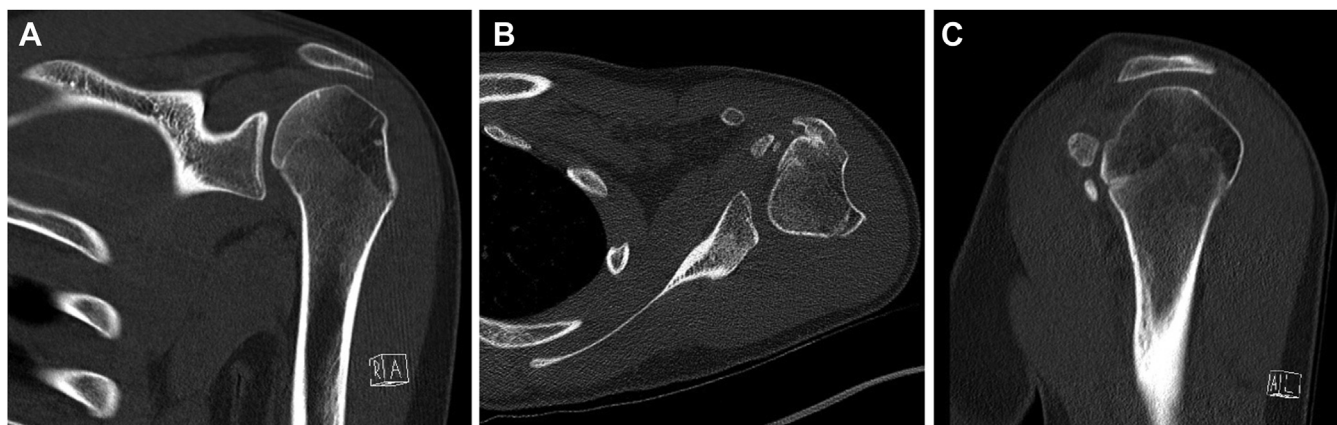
Preoperative computed tomography selected cuts of the left shoulder. (A) Select coronal cut showing significant superiorization of the humeral head and previous greater tuberosity fracture line. (B) Select axial cut showing fragmented malunion of the greater tuberosity anterior to the lesser tuberosity. (C) Select sagittal cut showing fragmented malunion of the greater tuberosity anterior to the lesser tuberosity.
